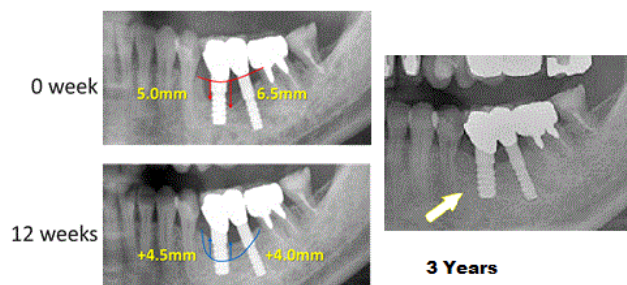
The amount of bone loss was 5.0 and 6.5mm at mesial and distal site of 20, respectively at 0 week. The mesial and distal levels of the peri-implant marginal bone were recovered radiographically at 12 weeks and this condition was stable following 3years.
